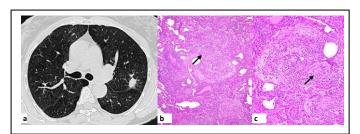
(a) axial computed tomography of chest showing nodule of GOP, (b and c) small poorly formed non-necrotizing granulomas of GOP (arrows).
